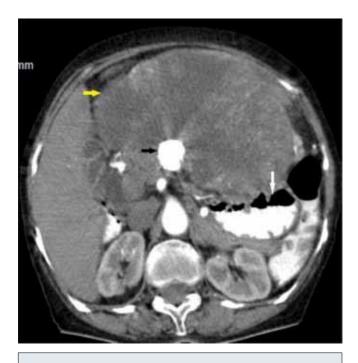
CT abdomen with intravenous and oral contrast showing non-homogenous enhanced lobulated intraperitoneal mass (yellow arrow) with central calcification (black arrow), pushing stomach from anterior side (white arrow).
